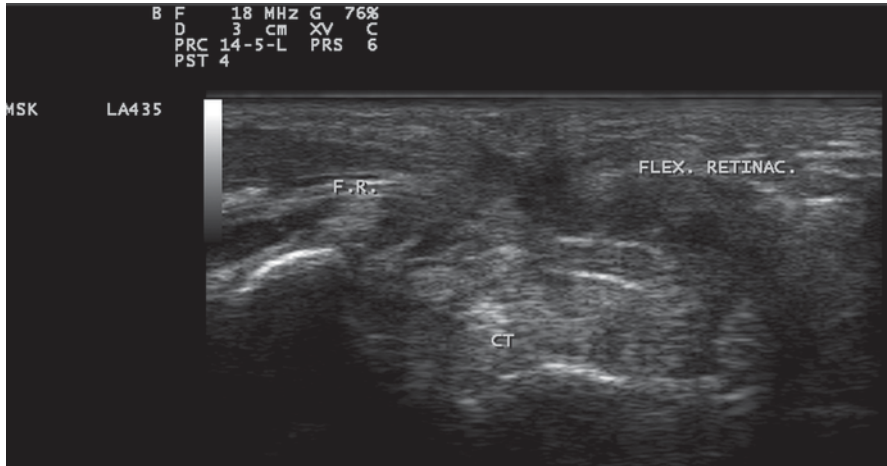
Gray scale US using Esaote Mylab 25 system: Palmar transverse view of the carpal tunnel showing postoperative decompression of the carpal tunnel with excision of the middle section of the transverse carpal ligament. *Flex. Retinac.* flexor retinaculum, *CT* carpal tunnel, *F.R.* Flexor retinaculum
